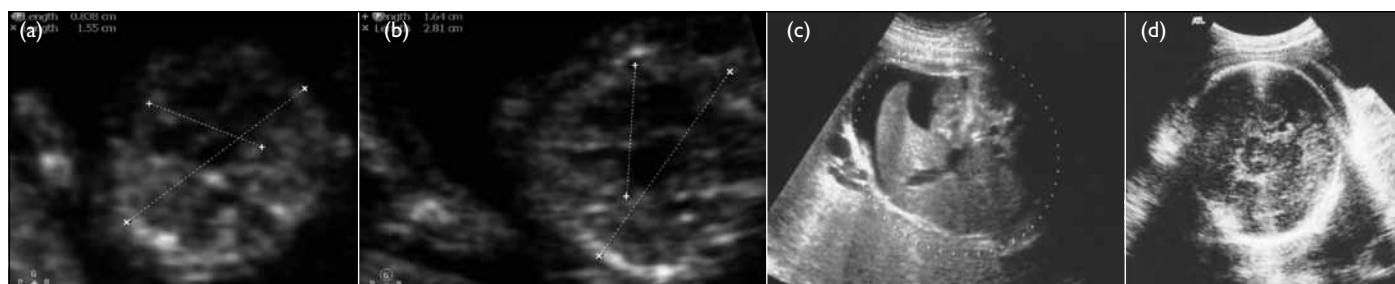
Ultrasound features of fetal haemoglobin Bart's disease
